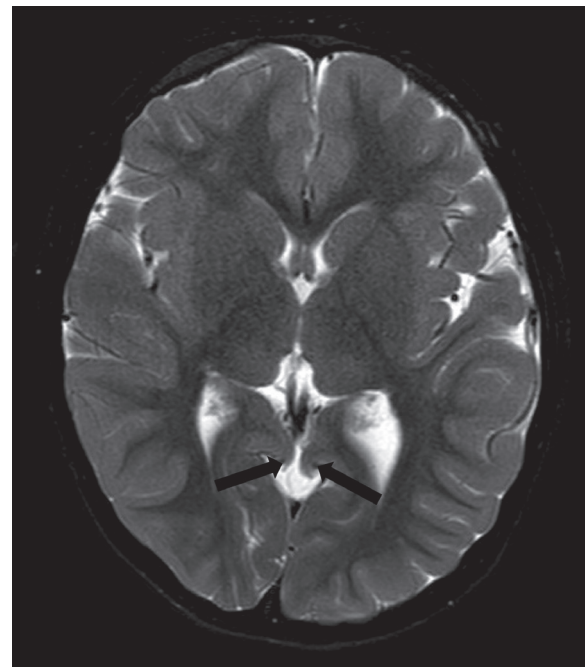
In another case, axial T2-weighted MR image shows bilateral cuneate gyrus herniation (black arrows)
